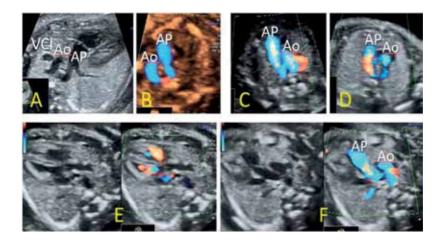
Right aortic arch (RAA) types. RAA and left ductus, forming a "U" shape of the arterial arches confluence as an almost complete vascular ring (A and B). Note the aorta coursing to the right of the spine, on the same side with superior vena cava (A), and a visible vascular incomplete ring behind the trachea. Double aortic arch, color Doppler evaluation (C and D) with complete vascular ring between the aortic branches. RAA with right ductus (E and F), described before with normal heart [44], duplex mode evaluation. Both arterial arches are directed to the right of the spine, resulting a "V"-shaped confluence on the right of the spine.
